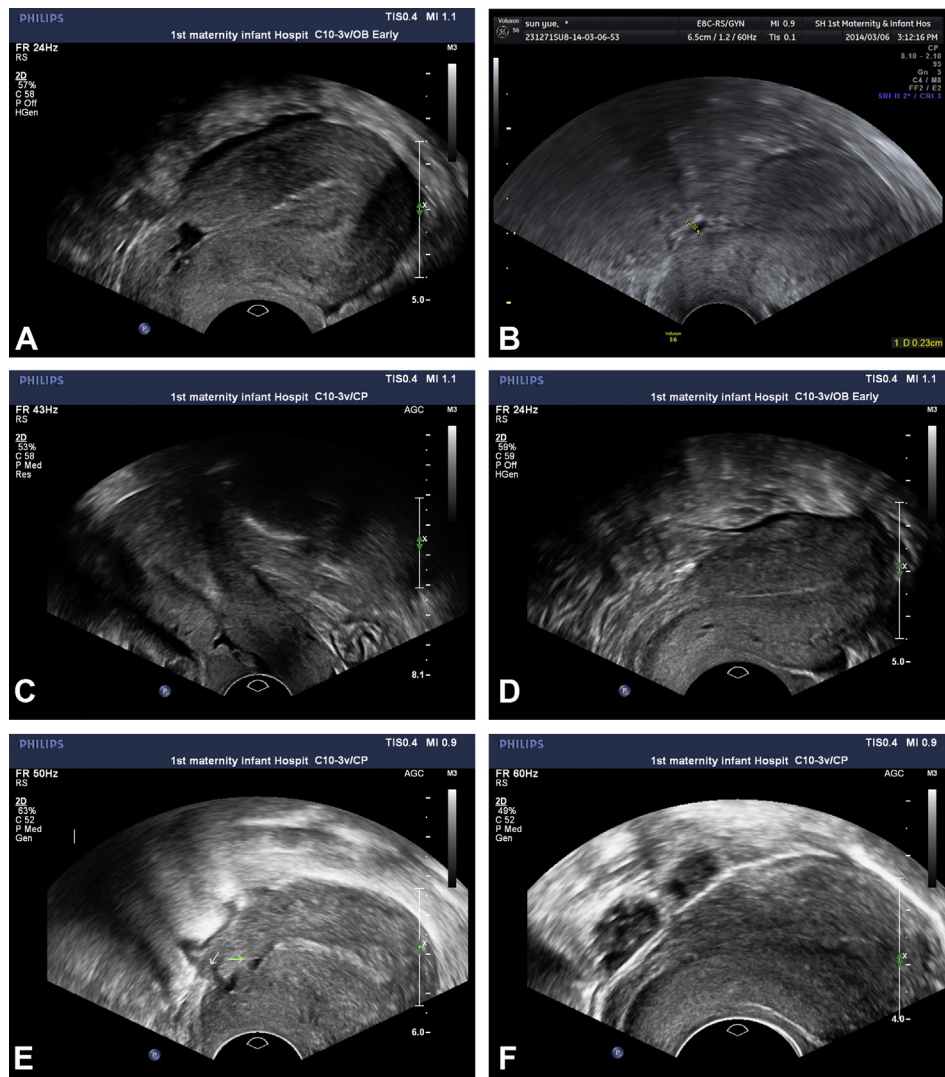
Figure 1. (A) Sonography image of case 1, before operation. (B) Sonography image of case 1, after operation. (C) Sonography image of case 2, before operation. (D) Sonography image of case 2, after operation. (E) Sonography image of case 3, before operation. (F) Sonography image of case 3, after operation.
